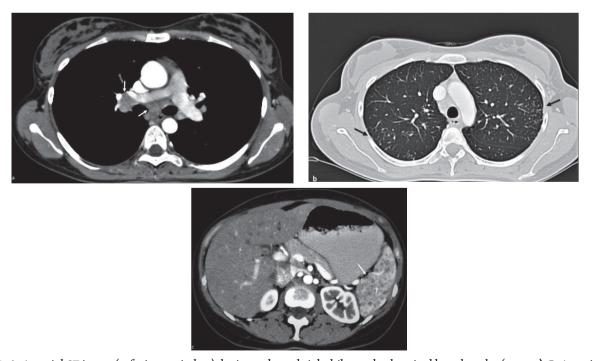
A: An axial CT image (soft tissue window) depicts enlarged right hilar and subcarinal lymph nodes (arrows). B: An axial CT image (lung window) shows multiple nodules in peripheral bronchovascular distribution (arrows), especially in the left upper lobe. C. Abdominal CT, axial plane, shows multiple hypodense nodules disseminated within the splenic parenchyma.
